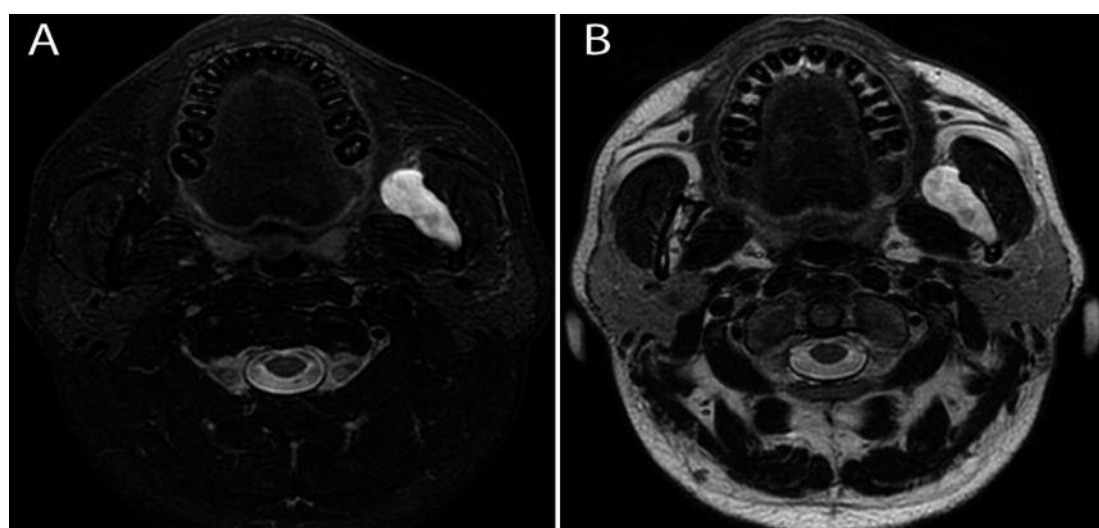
T2-weighted axial images acquired with a fast spin echo interactive decomposition of water and fat with echo asymmetry and least-squares estimation (FSE IDEAL). Water (A) and Fat (B) (T2 FSE-IDEAL) show an heterogeneous pattern within the solid/multicystic ameloblastomas tumour mass.
